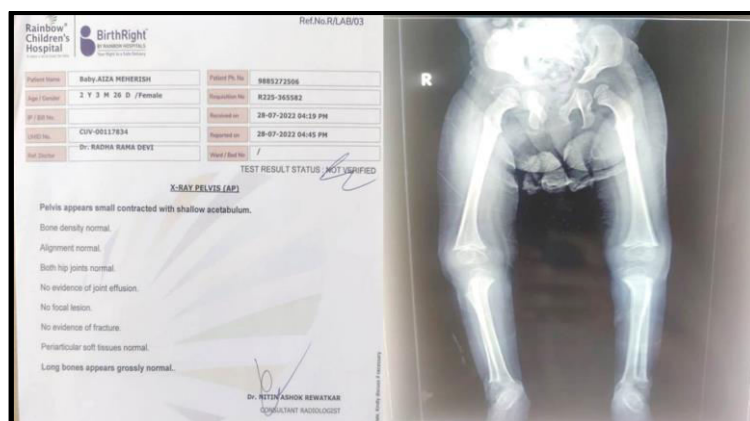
Showing Pelvic and Long Bone X-Ray
